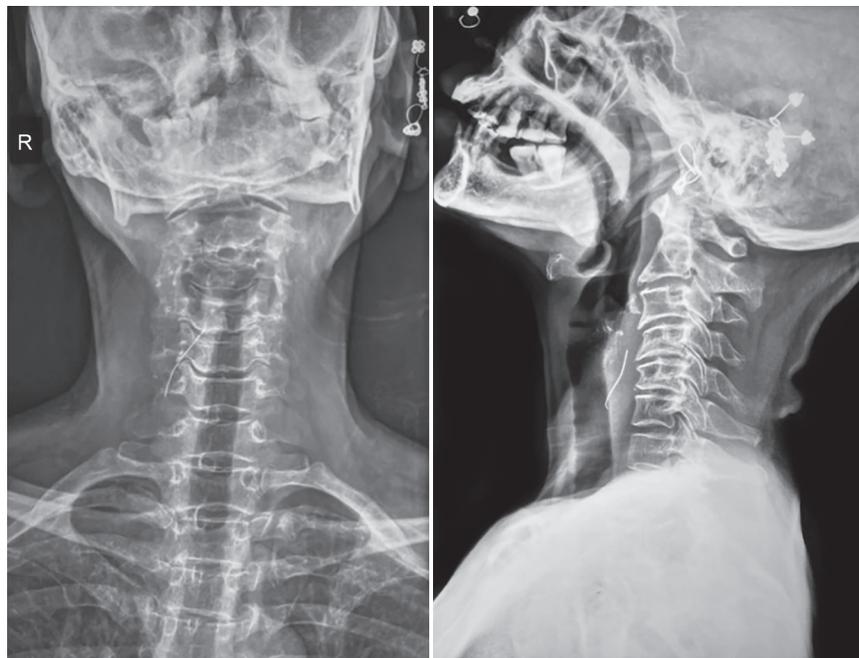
X-ray neck AP and lateral views
